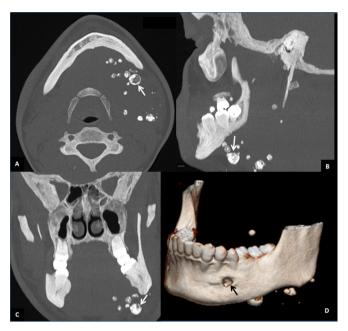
CT images (bone window). (A) Axial cut. (B) Sagittal cut. (C) Front cut. Mandibular bone asymmetry can be observed, with a reduction in the height of the mandibular body on the left side. An increase in the volume of the soft tissues, containing phleboliths, can also be identified (arrows) on the left side of the mandible. (D) 3D Reconstruction. A bone defect can be observed in the vestibular cortex located in the left mental foramen region.
